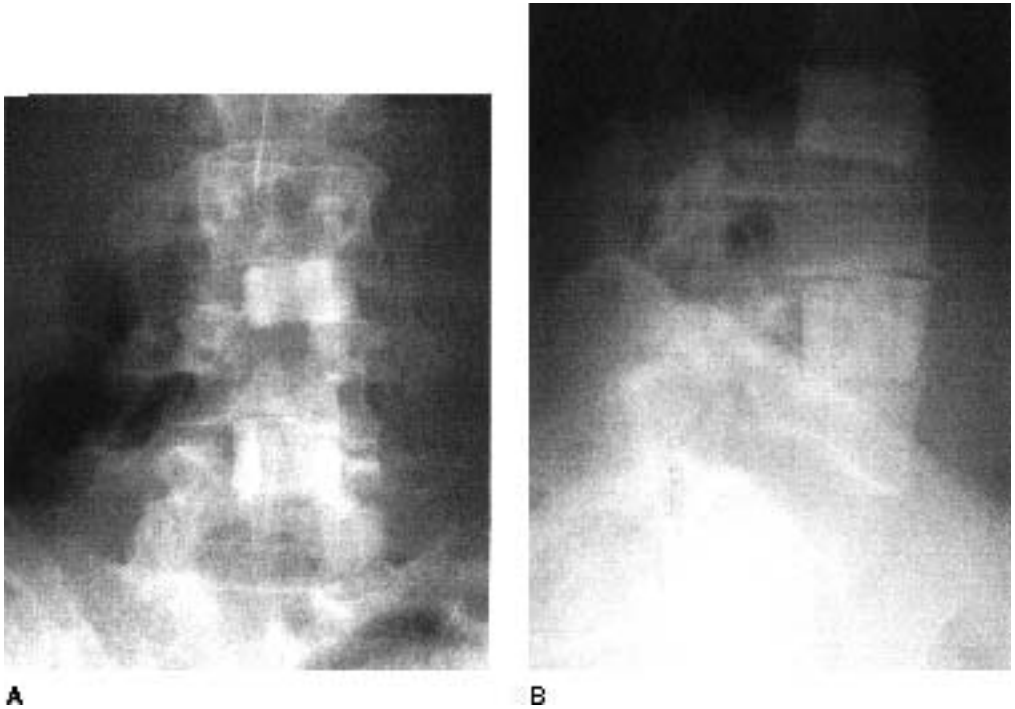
(A) Anteroposterior and (B) lateral radiographs of the lumbar spine show two femoral ring allografts placed centrally in the L3–4 and L4–5 disc spaces. The vertebral end plates have been prepared to uniformly contact the structural allografts. These impacted grafts act as spacers and require no supplemental fixation to stabilize the interface between the host bone and allograft. The grafts are recessed to prevent extrusion.
